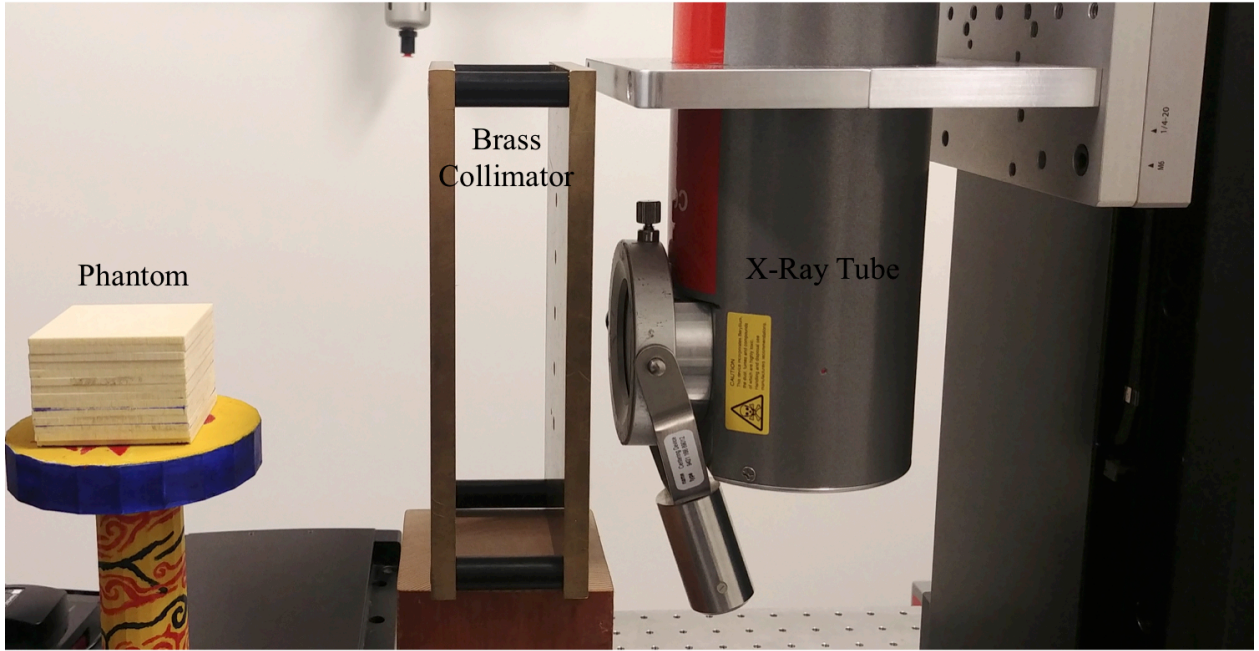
Photograph of the tabletop x-ray tube experimental setup.
